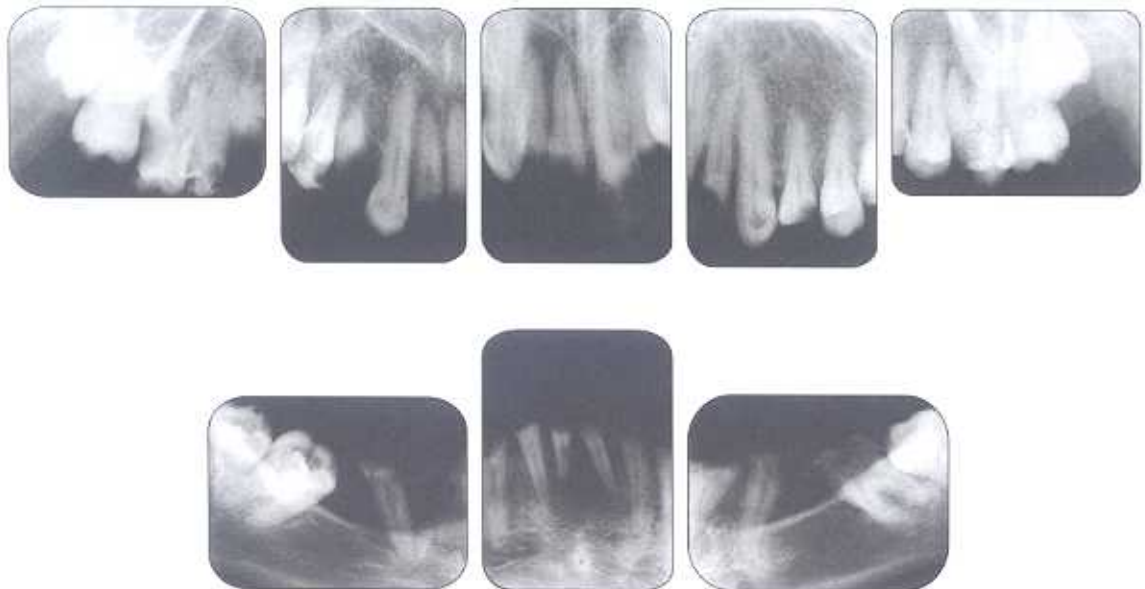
Periapical radiographs showing the thinning of the pulp chambers and alveolar bone loss in the mandibular right premolar and mandibular incisor area and the integrity of lamina dura.
